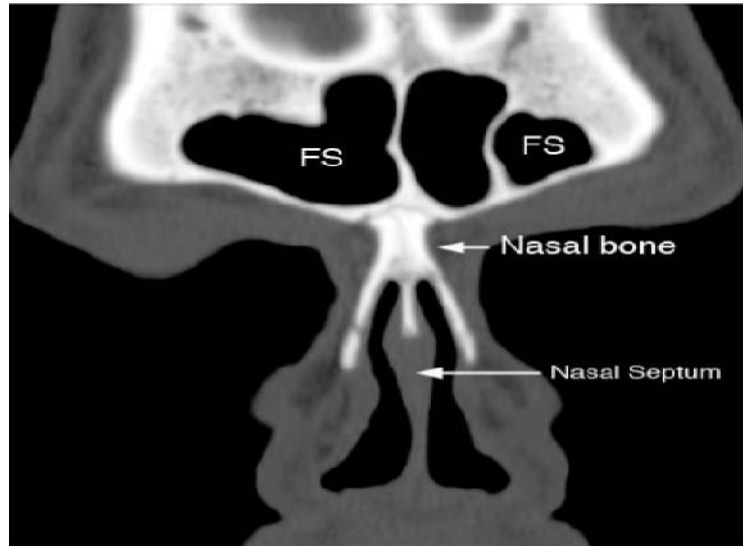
Coronal and Axial CT images showing normal frontal sinus (FS) anatomy
